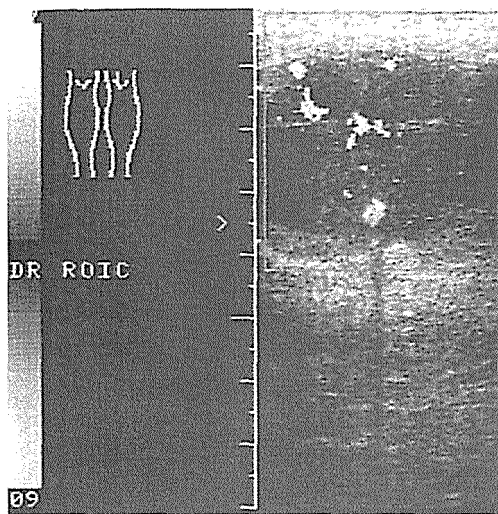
Foreign body - colour Doppler. Colour flow Doppler imaging shows increased blood flow in the hypoechoic mass; central hyperechoic focus with acoustic shadowing - foreign body (metal silver).
